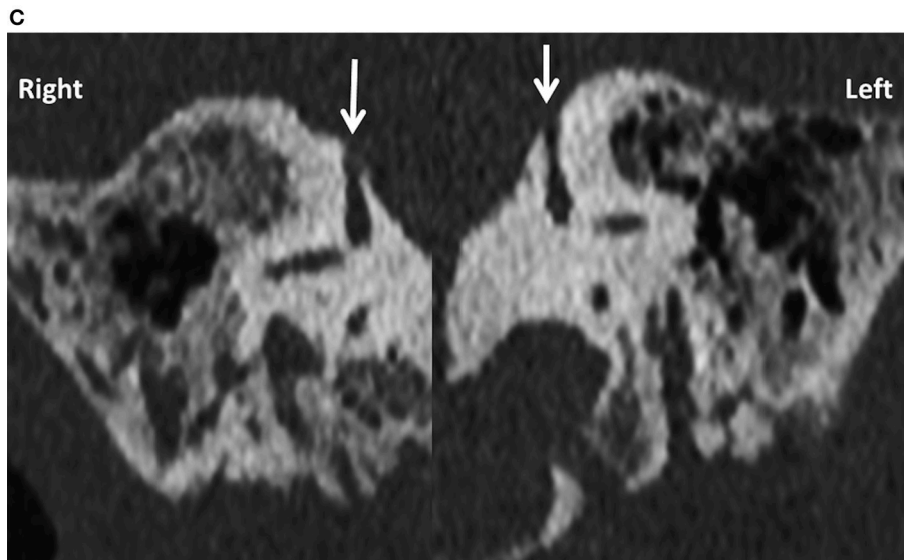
(A) PTA in a child presenting with conductive hearing loss on both sides (child 6). (B) Video head impulse test in the same child with overt replicable saccades in the left lateral semicircular plane (arrow). (C) Coronal reconstruction of High resolution CT scan shows dehiscence of the superior semicircular canal on both sides (arrows).
